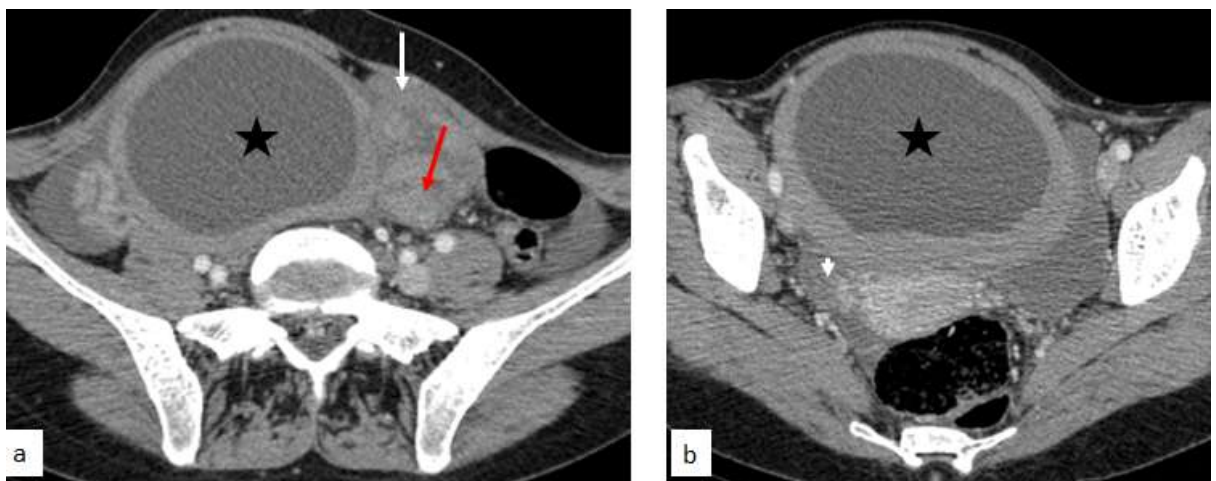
Injected pelvic CT scan (a,b) in axial section showing an enlarged left ovary, measuring 15 x 10 cm, with a cystic lesion (star), measuring 11 x 7 cm, turgidity of the left ovarian pedicles (white arrow), with individualization of a turn of spire (red arrow). Normal right ovary (arrowhead).
